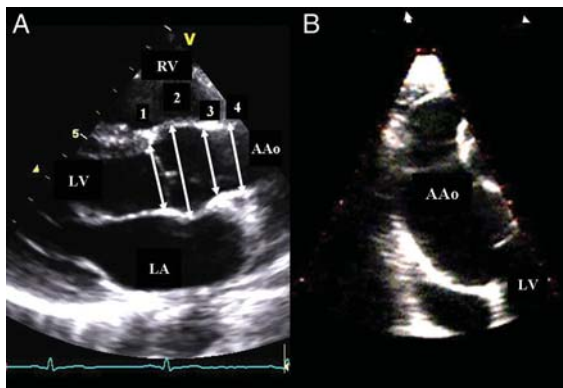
Transthoracic echocardiography. (A) Parasternal long-axis view (transthoracic echocardiography). The following diameters are shown: outflow tract diameter (1), sinuses of Valsalva (2), sinotubular junction (3), and tubular ascending aorta (4). (B) Right parasternal long-axis view, mid and distal parts of ascending aorta may be visualized. AAo, ascending aorta; LA, left atrium; LV, left ventricle; RV, right ventricle.
